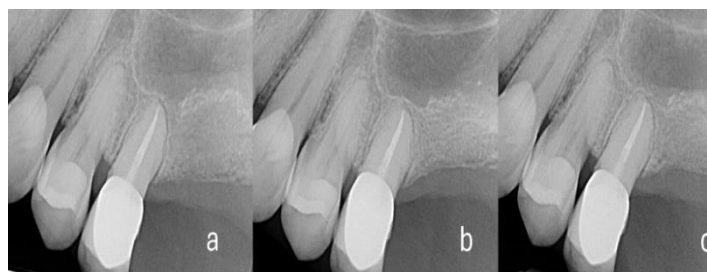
Radiographic follow-up after 2 months (a), 4 months (b) and 6 months (c) of healing, showing a progressive, but limited, volumetric contraction of the grafted area.
